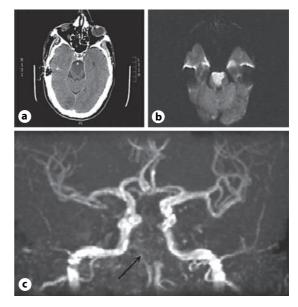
a CT scan showing a hypodense area within the pons and hyperdensity of the basilar artery. b Diffusion-weighted MRI showing recent infarction of the pons. c Angio-MRI showing occlusion at the origin of the basilar artery (arrow).
